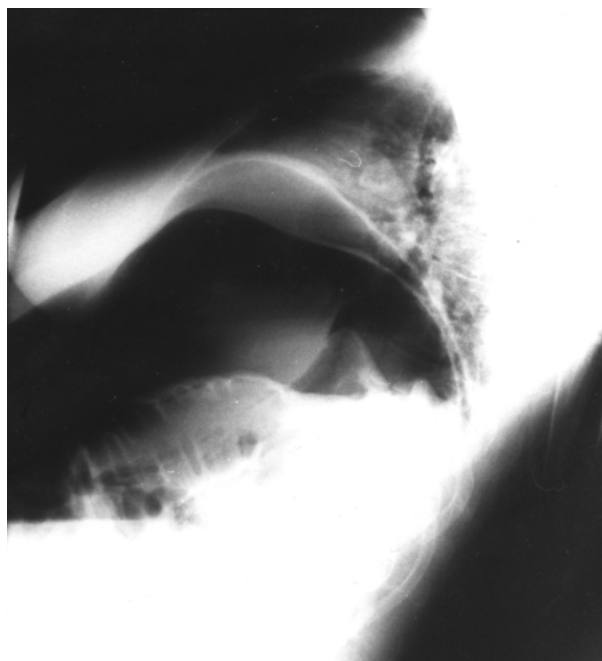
Upright lateral chest radiograph of the case patient showing pneumoperitoneum.
